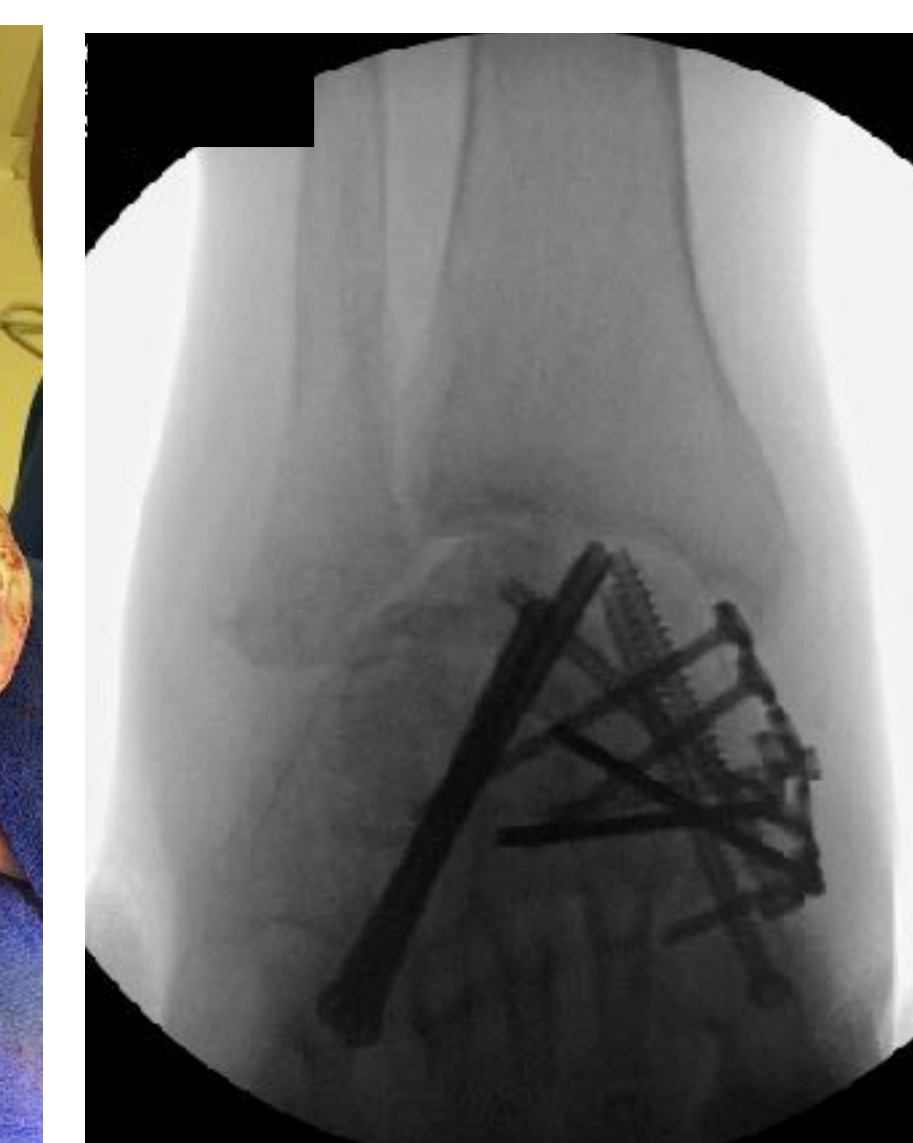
Intra-op AP ankle radiograph demonstrating re-alignment of the ankle mortise following arthrodesis of the foot & repair of the deltoid ligament using the EDL 4th tendon.
